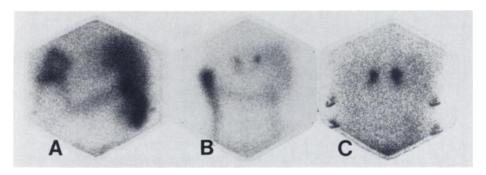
Examples of posterior NP-59 scintigrams. (a) Image obtained three days after NP-59 administration in patient without bowel preparation; all three observers felt bowel activity interfered with evaluation of adrenal glands. (b) Image obtained three days after NP-59 administration in patient without bowel preparation. Cushing's disease study without dexamethasone. (c) Image obtained three days after NP-59 administration in patient with bowel preparation. Cushing's disease without dexamethasone administration.
